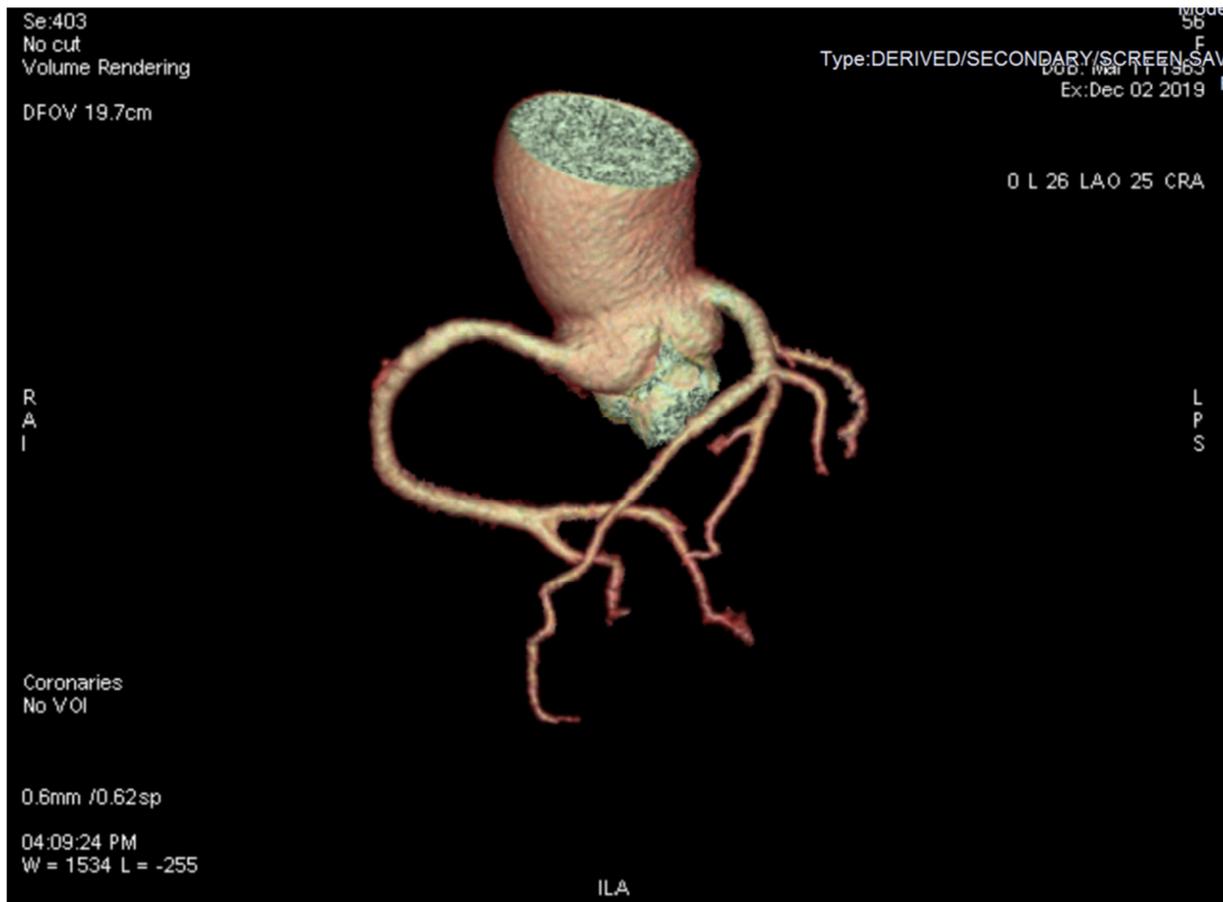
Coronary computed tomography after operative showed the absence of thrombotic occlusions in left or right coronary artery.
